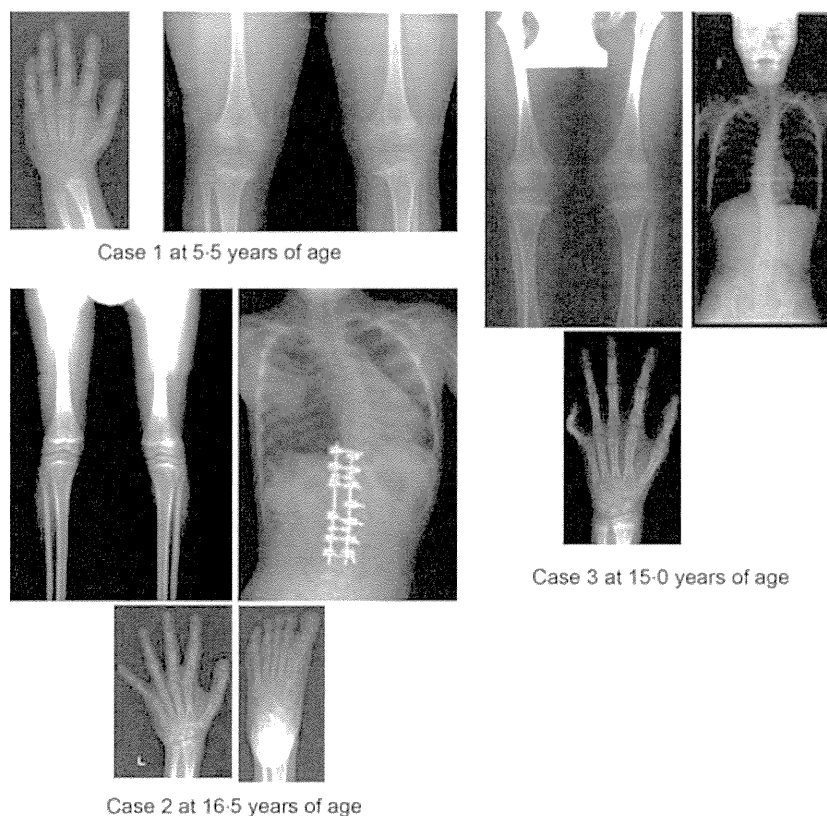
Representative skeletal roentgenograms in cases 1–3.
